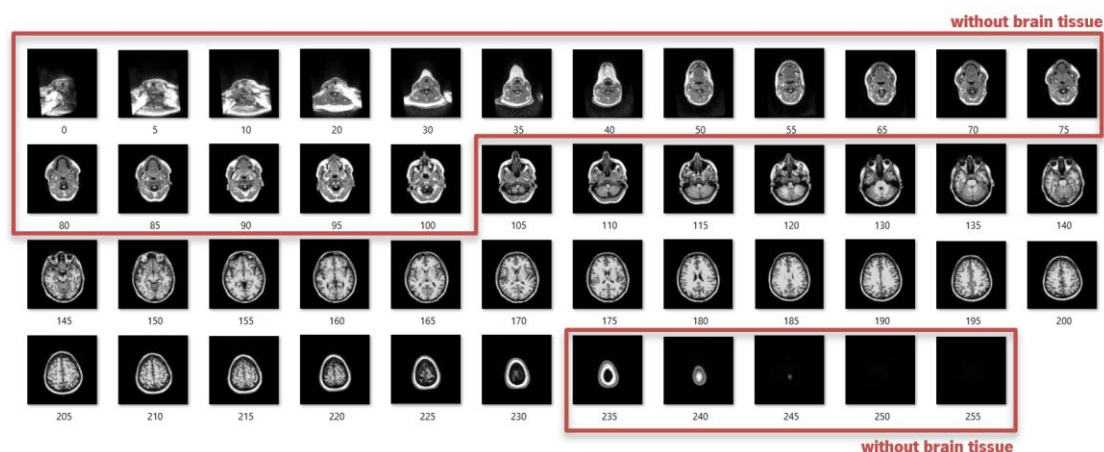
Unbalanced data issue found using axial slices of MRI
